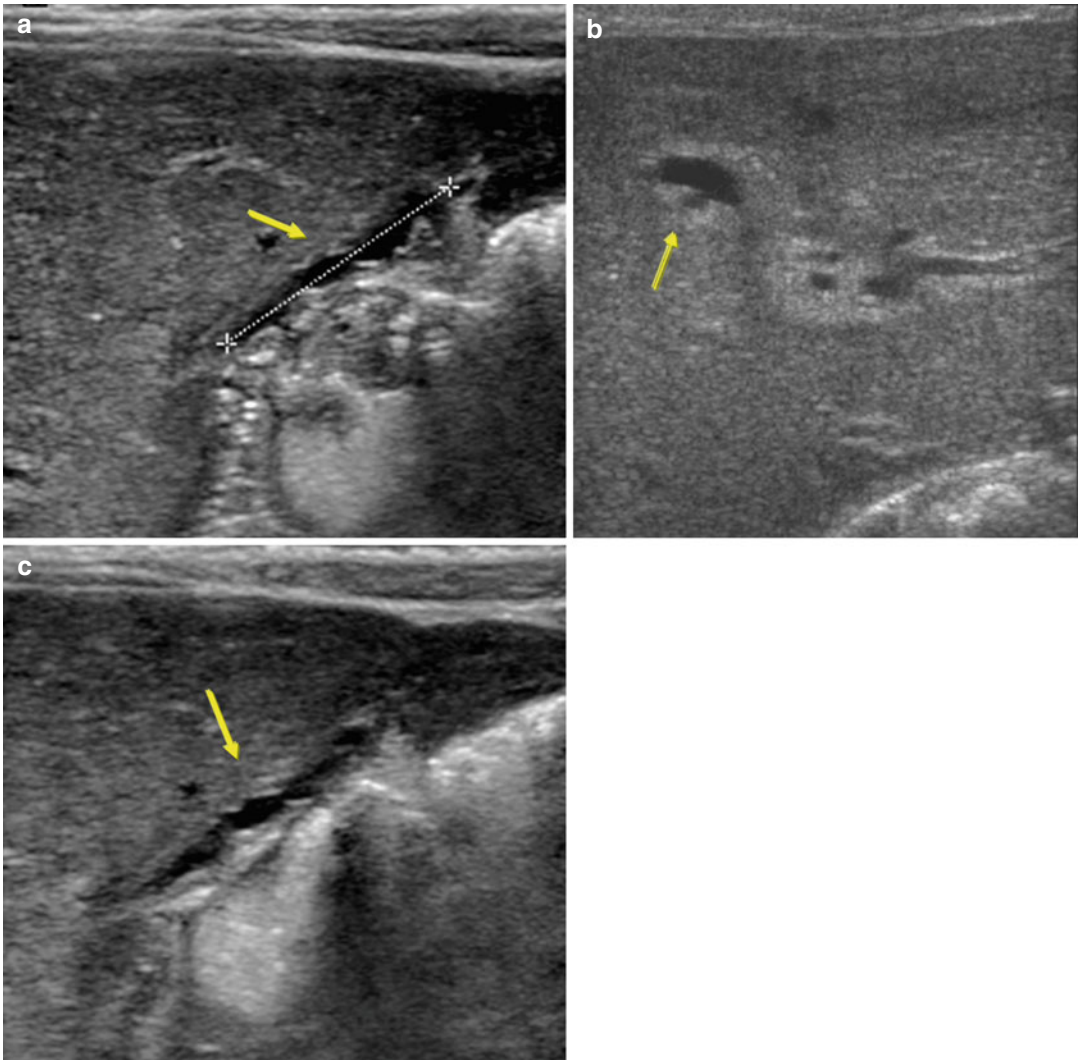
Sonographic scans show the “gallbladder ghost triad.” (a) Atretic gallbladder less than 1.9 cm in length; (b, c) thinned or lack of a smooth, complete echogenic
